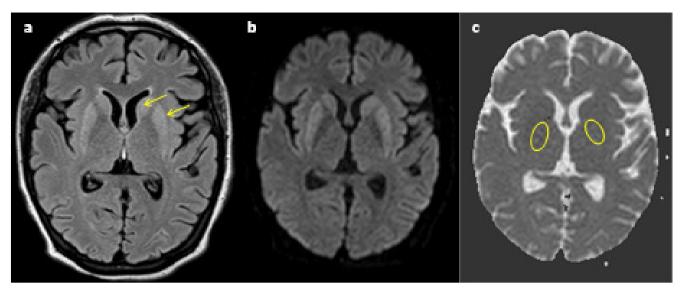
FLAIR (a) and DWI (b) images, 1.5 months after the insult, shows abnormal signal in the putamen and caudate nuclei; ADC map (c) shows elevated values in both globus pallidus, but greater on the right side, indicating greater involvement.
